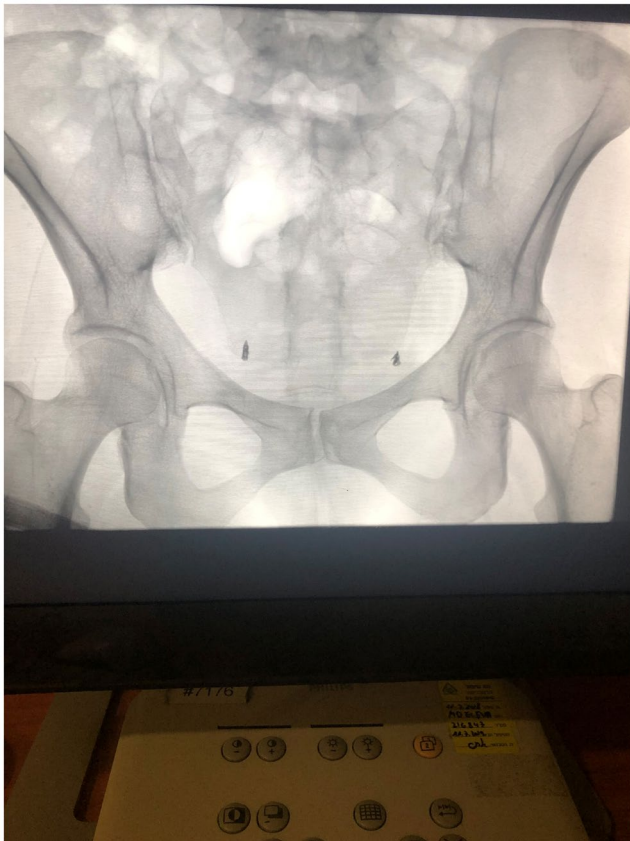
X-ray of the anchors and their relations in the pelvis
